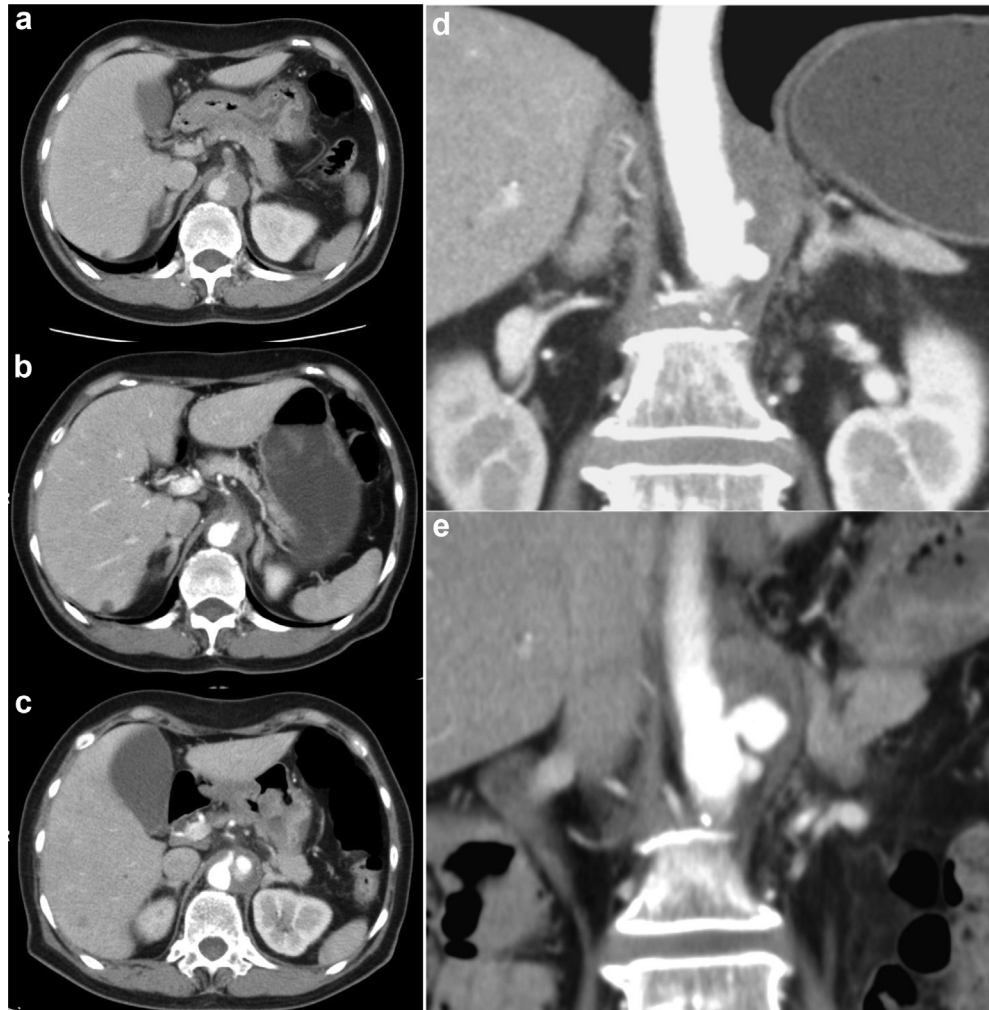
Representative preoperative computed tomography angiography images of the aorta performed (a) 60 days, (b and d) 14 days, and (c and e) 1 day before the operation. The thoracoabdominal aorta showed rapid expansion accompanied by celiac trunk occlusion.
